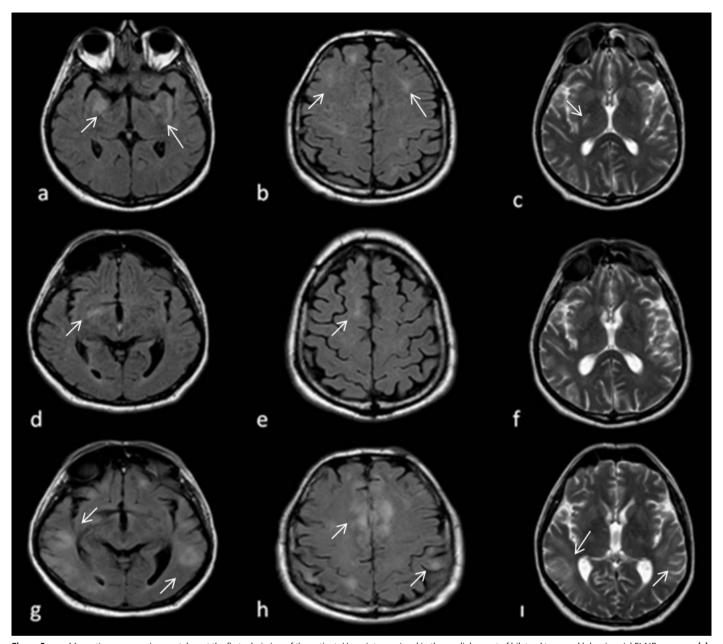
a-c. Magnetic resonance images taken at the first admission of the patient. Hyperintense signal in the medial aspect of bilateral temporal lobes in axial FLAIR sequence (a). Hyperintense signal in cortical regions in axial FLAIR sequence (b). Subcortical hyperintense signal in axial T2-weighted image (c). Magnetic resonance imaging findings at the 2nd month, when the lesions regressed after treatment (d, e, f). Magnetic resonance images of the 4th month relapse period in which the increase in cortical and subcortical lesions is observed in axial T2-weighted and FLAIR sequence (g,h,i) (arrows).
